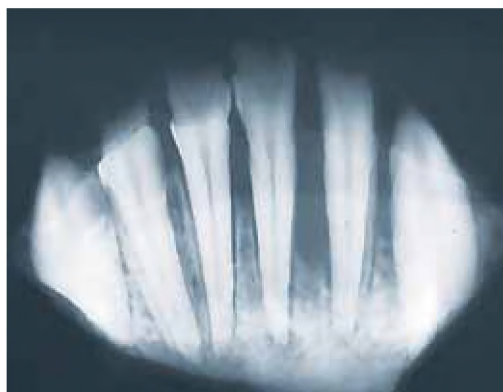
Intraoral x-ray showing a vertical and horizontal loss greater than 50% of the basal bone. Courtesy of Dr John Fantasia, Chief of the Department of Oral and Maxillofacial Pathology, North Shore Long Island Jewish Medical Center, USA.
